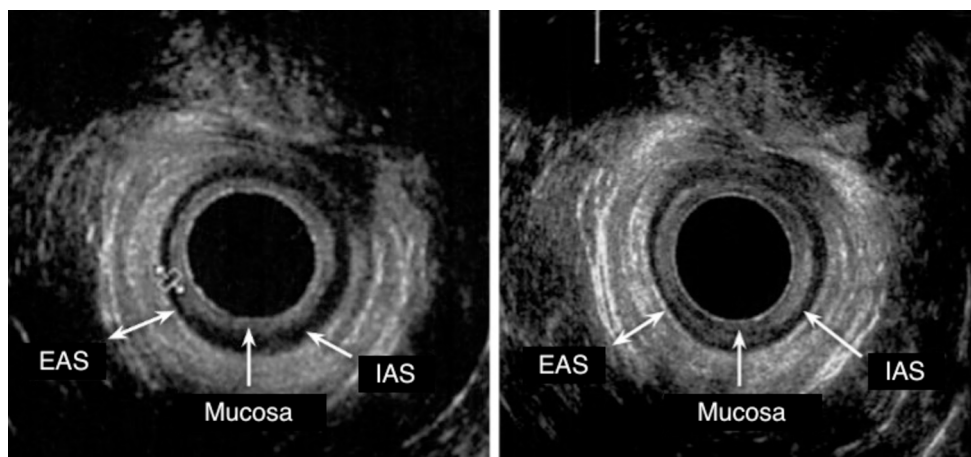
Endoanal ultrasound before and after caesarian section (Mucosa: Anal Mucosa; EAS: external anal sphincter; IAS: internal anal sphincter).
